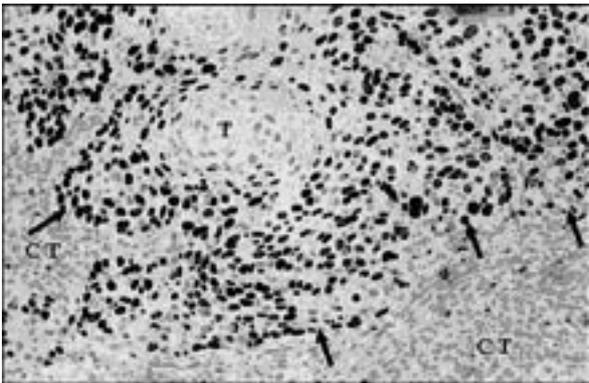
Immunoreactivity of p53 at the tumour invasive front of SCC in buccal mucosa. A striking accumulation of p53 positive tumour cells is seen at the tumour invasive front as well as in peripheral layers of invading tumour islands. However, the central keratinizing areas in most tumours are virtually p53 negative. Arrows showing tumour invasive front. T – Tumour area; CT – Connective tissue area. (Original magnification X50).
